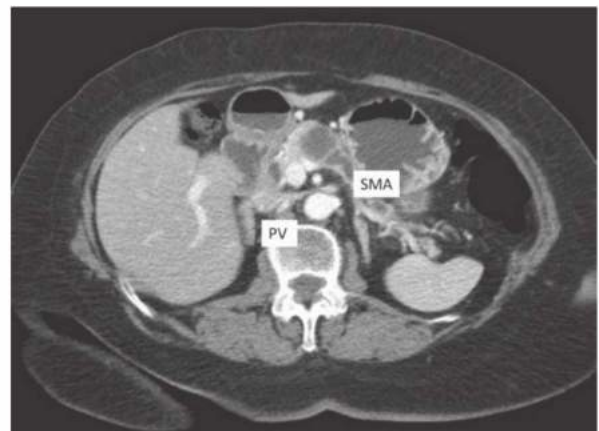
● CT of a resectable pancreatic cancer. PV, portal vein; SMA, superior mesenteric artery.
